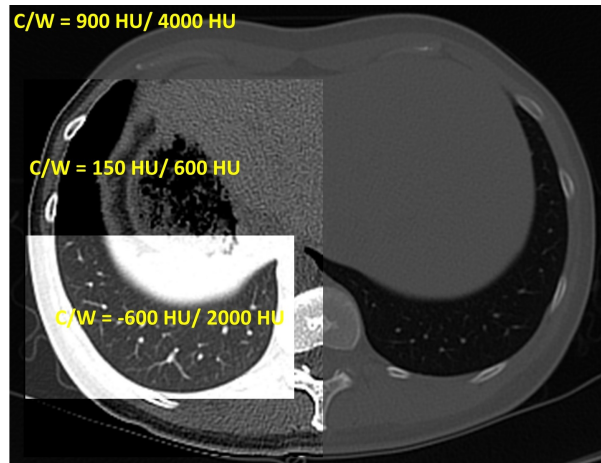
Different examples for window/level settings in CT. A typical lung window ($C = -600$ HU, $W = 1200$ HU), a window for soft tissue ($C = 150$ HU, $W = 600$ HU) and bones ($C = 900$ HU, $W = 4000$ HU) are shown.
